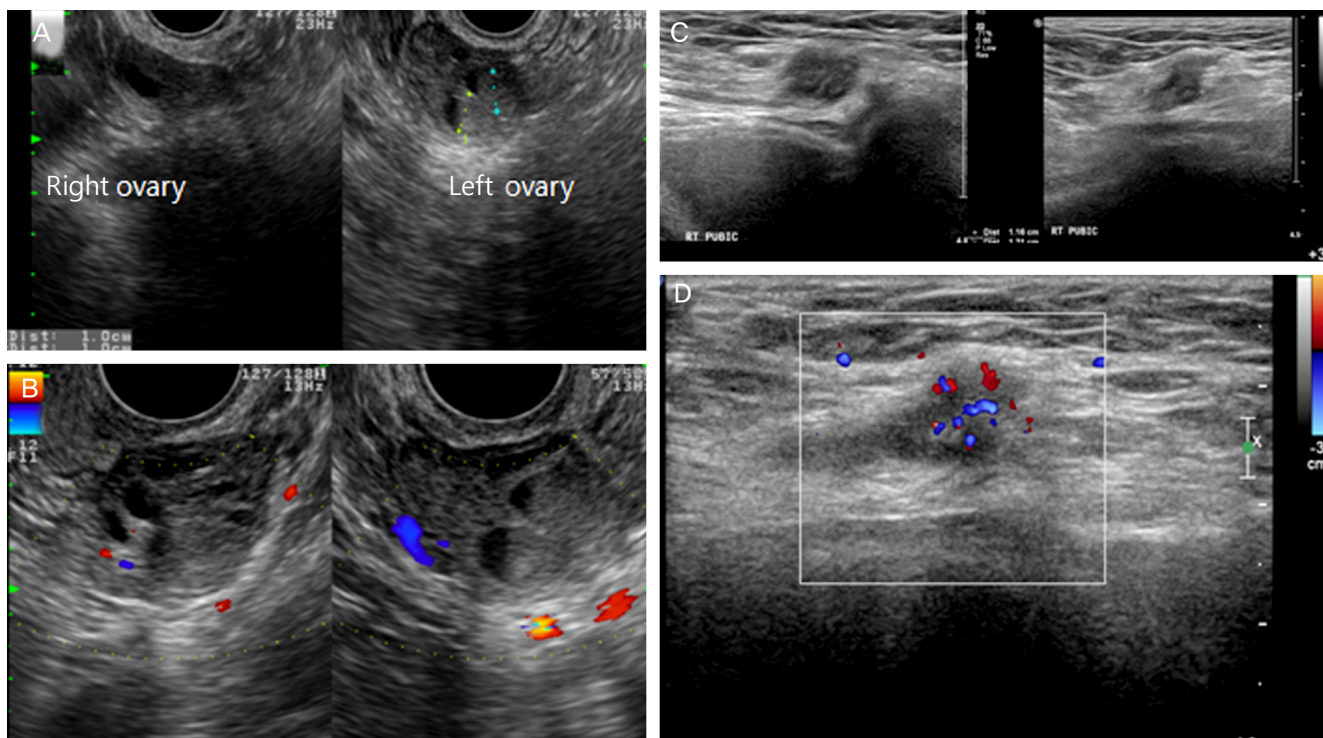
Transvaginal ultrasonographic findings of the adnexa and inguinal mass. (A) Right ovary was grossly normal. Left ovary showed two low-echoic cysts. (B) Doppler transvaginal ultrasonographic findings of the left ovarian cyst. The longitudinal and transverse view showed two low-echoic cysts of 1.0 cm size. (C) Inguinal ultrasonographic findings of the inguinal mass. The longitudinal and transverse views show an ill-defined hypoechoic lesion (size, 1.1×1.2 cm). (D) On Doppler ultrasonographic findings showed increased vascularity of the mass in the right pubic area.
